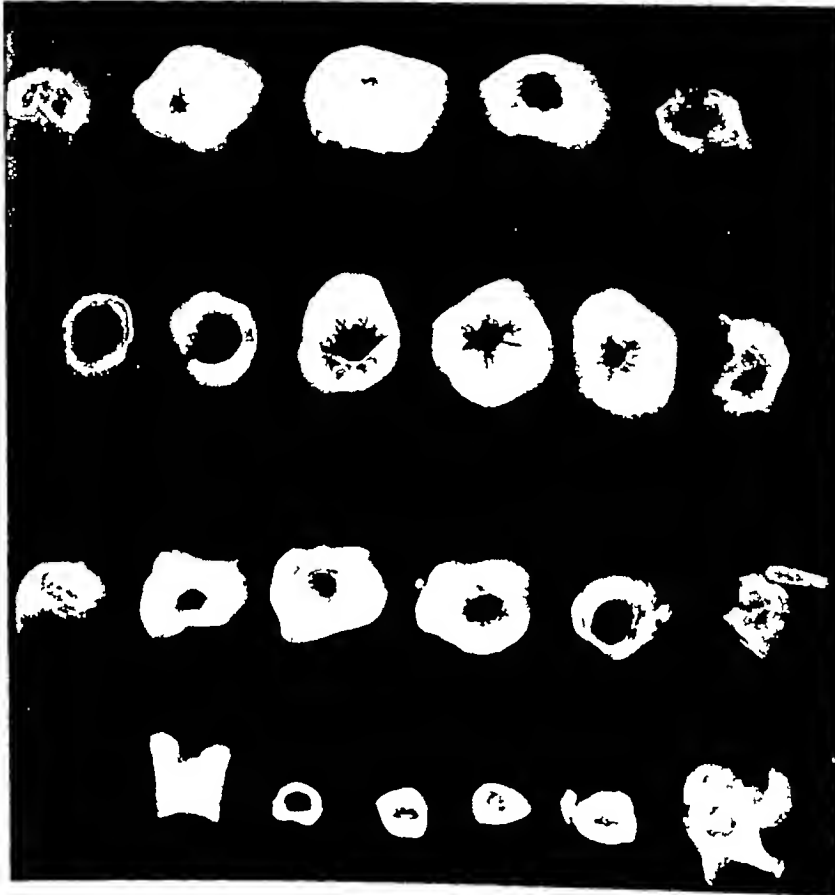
Roentgenograms of cross sections of a normal (bottom) and three osteopetrotic tibiae.
